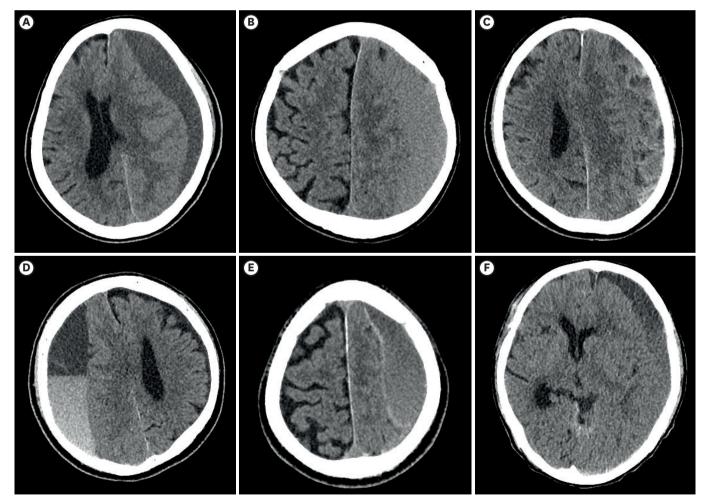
CT imaging of different types of CSDH. (A) Homogeneous hypodensetype, (B) Homogeneous isodense type, (C) Trabecular type, (D) Separate type, (E) Laminar type, and (F) Gradation type. CT: computed tomography, CSDH: chronic subdural hematoma.
